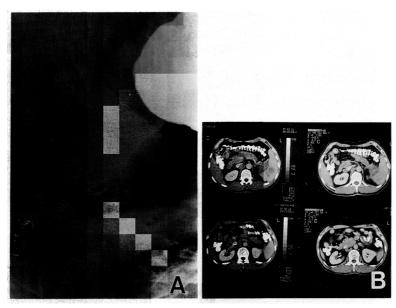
A: UGI study shows the ulcero-infiltrative lesion in the antrum. B: Abdomino-pelvic CT shows retro-pancreatic, para-aortic, peri-splenic and splenic mass lesions.
